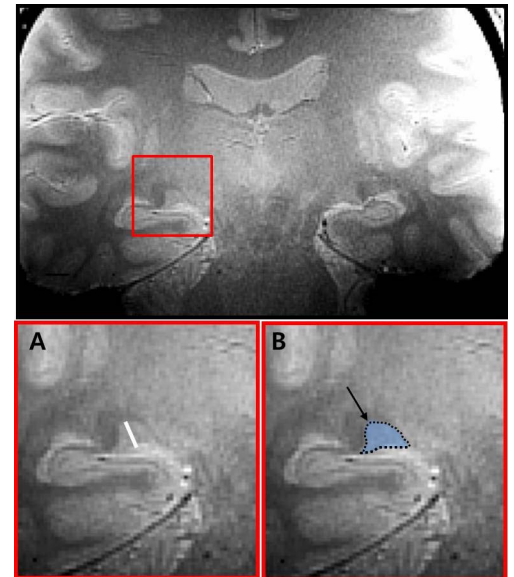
LGN image using 7.0T MRI (top). (A) White lines used for LGN height measurement. (B) The black arrows indicate segmented LGN (blue area).
